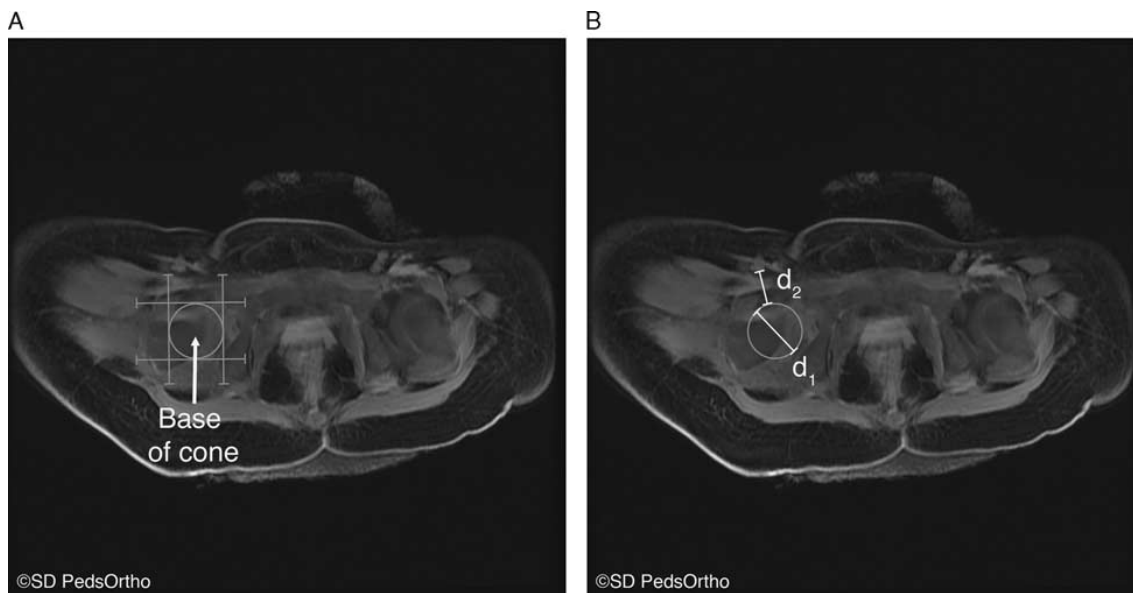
A, The same axial magnetic resonance image from previous figures with the 4 borders outlined, with a fit to match circle embedded. The circle makes up the base of the cone. B, Measurements can then be made of the base of cone diameter (d_1) and the distance from the base of the cone to the FNV (d_2).
